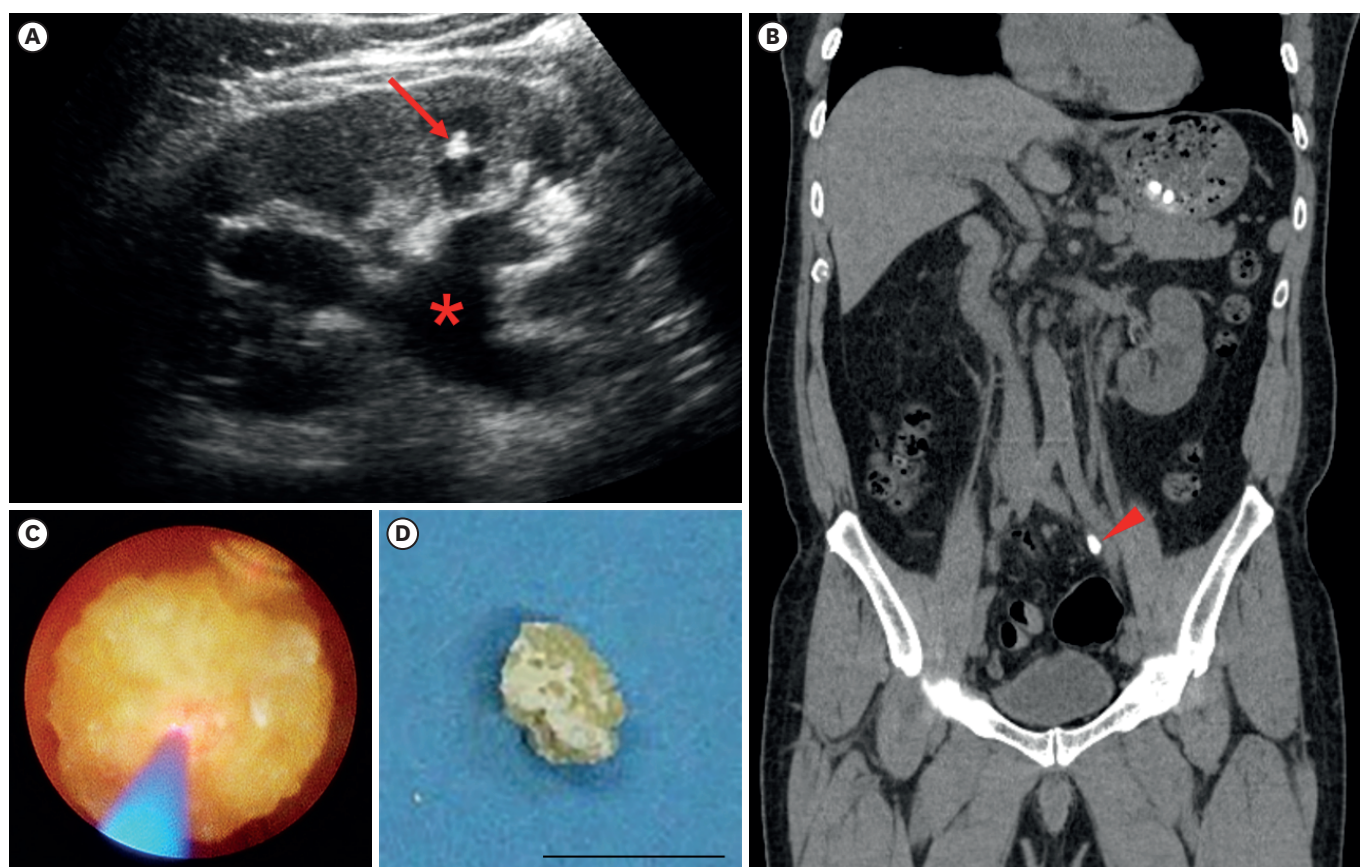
Clinical findings on the diagnostic work-up for cystinuria. Findings of ultrasonography (A), computed tomography (B), retrograde ureteroscopy (C), and gross appearance of the cystine stone (D).
